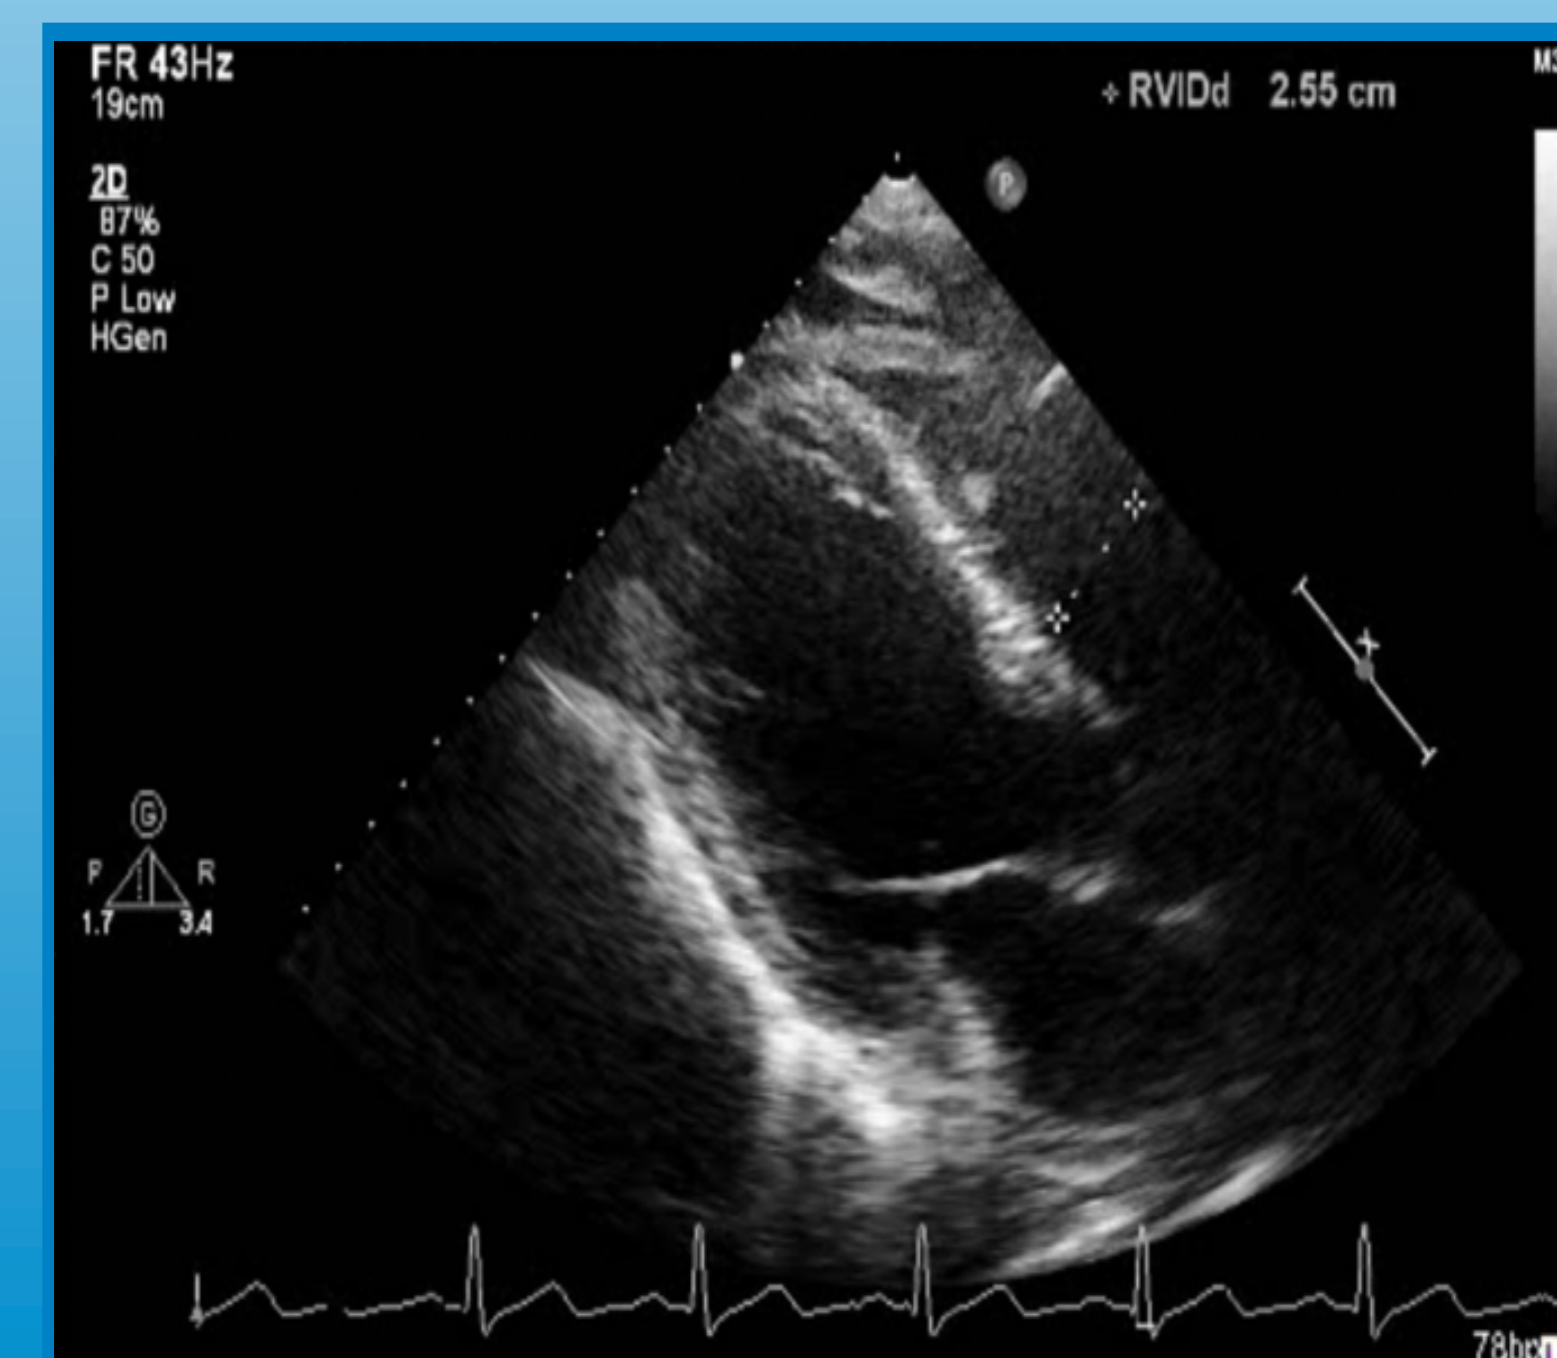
Parasternal long-axis view of a TTE that did not show any valvular abnormalities.
